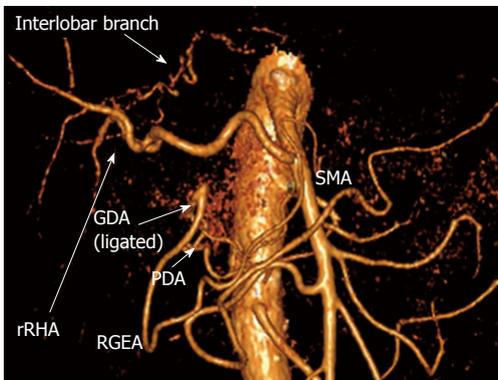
Three-dimensional computed tomography angiography subsequent to distal pancreatectomy with excision of celiac artery, left gastric, common hepatic and left hepatic arteries. Blood supply to right hepatic lobe is provided by superior mesenteric artery (SMA) through the replaced right hepatic artery (rRHA) and that to left hepatic lobe - via interlobar collateral anastomosing with rRHA. Stomach is supplied from SMA via pancreaticoduodenal artery (PDA) and, thereafter, through gastroduodenal artery (GDA) and right gastro-epiploic artery (RGEA).
